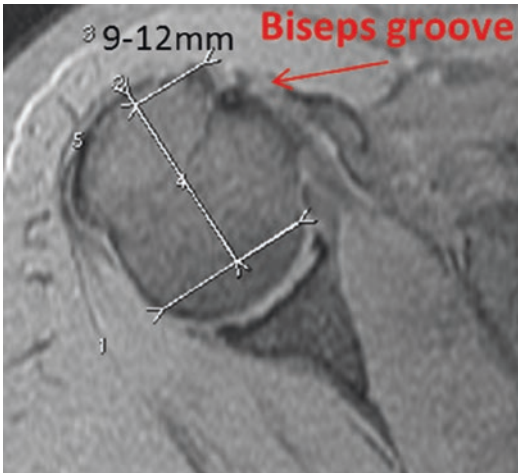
The distance between the bicipital groove and the line bisecting perpendicularly the line drawn from anterior articular edge to posterior articular edge of the humeral head in the transverse plane of the shoulder magnetic resonance imaging that the humeral head is observed in greatest dimensions shows the appropriate localization of the prosthesis lateral corner to constitute the anatomic version
